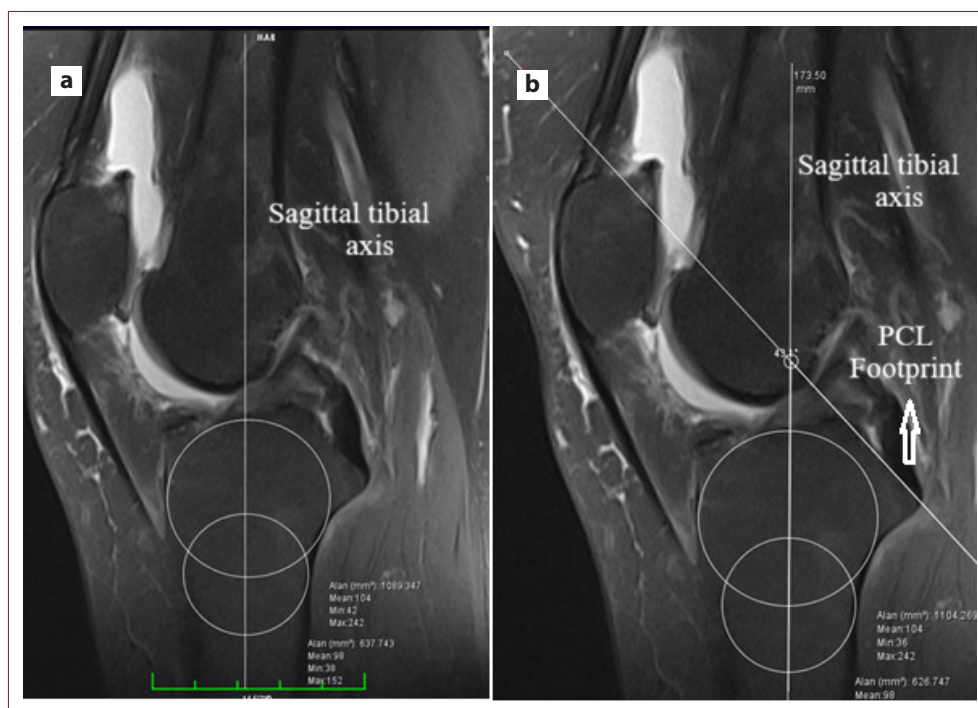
Measurement of the PCL tibial footprint angle (PCL-FPA) on sagittal MRI. (a) The sagittal tibial longitudinal axis is determined using the two-circle method on the sagittal MRI section where the PCL tibial attachment is best visualized. (b) A line is drawn parallel to the PCL tibial footprint (i.e., along the attachment surface of the PCL fibers on the tibia); PCL-FPA is then measured as the angle between this footprint line and the sagittal tibial longitudinal axis (arrow). Representative case: 59-year-old female with isolated degenerative MMPRT. PCL-FPA: 43.1°. (PCL-FPA: PCL footprint angle; PCL: posterior cruciate ligament; MRI: magnetic resonance imaging.)
